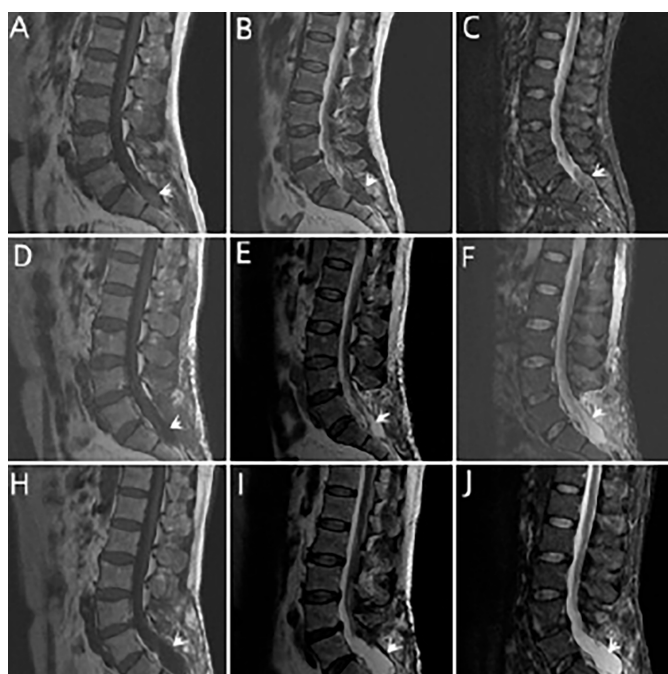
(A-C) Preoperative MRI scans, (D-F) MRI evaluation conducted one week post-surgery, (H-J) MRI re-assessment performed one year after the operation.
